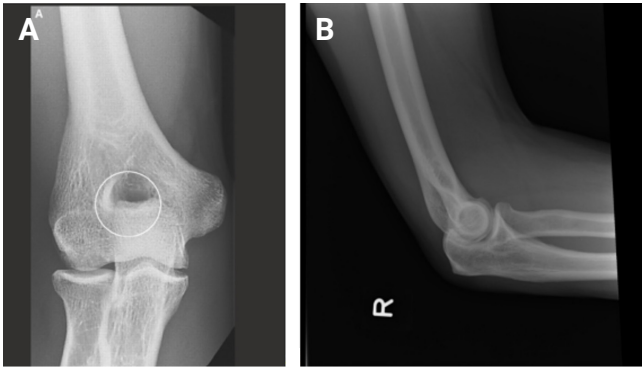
Osteophyte formation on the posterolateral corner of the olecranon on anteroposterior (A) and lateral (B) radiographs.
